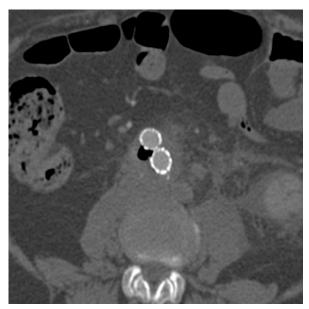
Preoperative computed tomographic angiogram shows periprosthetic fluid and gas collections associated with inflammation of the aortic wall.
